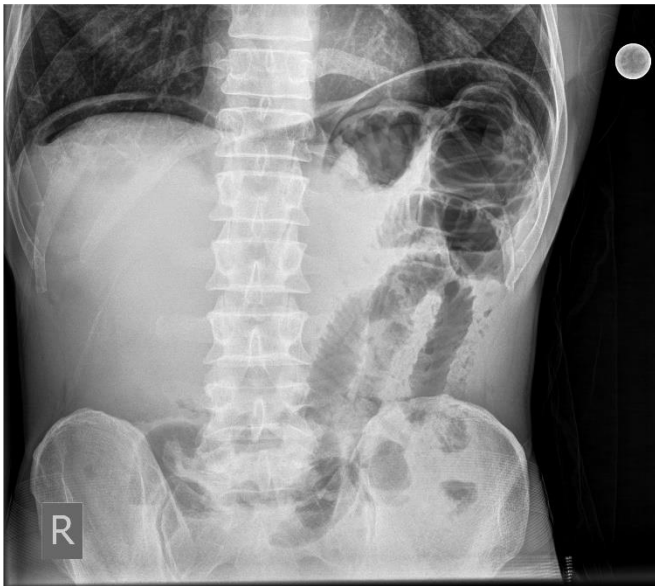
Plain abdominal x-ray in the upright position showing infra-diaphragmatic free air.
